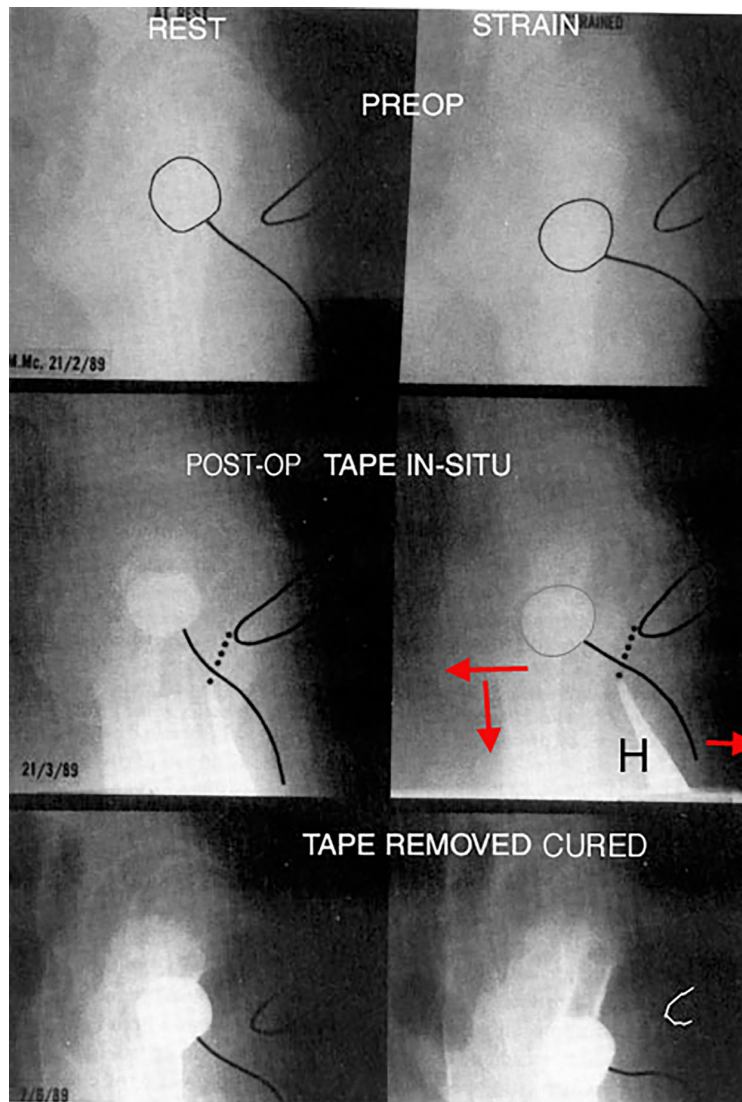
Standing sagittal xrays from 1990 prototype MUS, Same patient. Left column: at rest. Right column: straining. Middle xray right, post-op. Intravaginal tape grasped by a haemostat “H” reveals three directional forces acting in the position of PUL. Bottom Xray, post-op. Bladder neck below symphysis at rest and during straining. Patient cured. It was concluded that there were two closure mechanisms acting against a PUL of optimum length, one at distal urethra and the 2nd at bladder neck, activated by oppositely acting muscle forces, Figure 2
